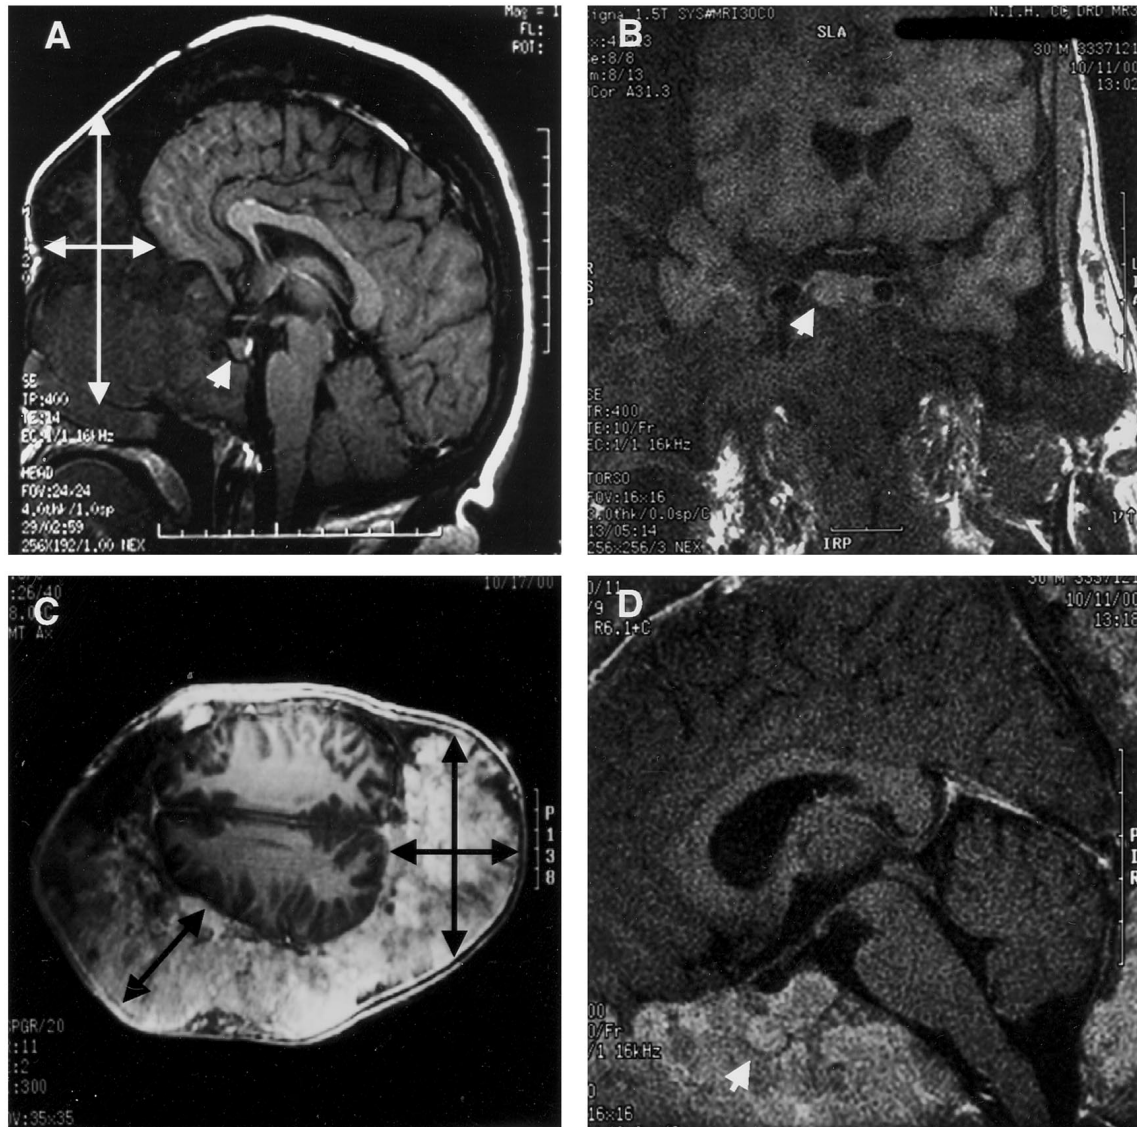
Cranial MRIs of patients with GH excess and MAS. The cranial MRI of patient 11 is shown in panels A and B and of patient 12 in panels C and D. Massive expansion of CF bones is demonstrated by the *white* (A) and *black* (C) arrows. The high degree of vascularity is evident on the gadolinium-enhanced image (C). *Arrowheads* indicate the pituitary adenoma in patients 11 (A and B) and 12 (D). Patients 11 and 12 had the highest serum IGF-I levels and the greatest degree of expansion of the CF bones with FD.
